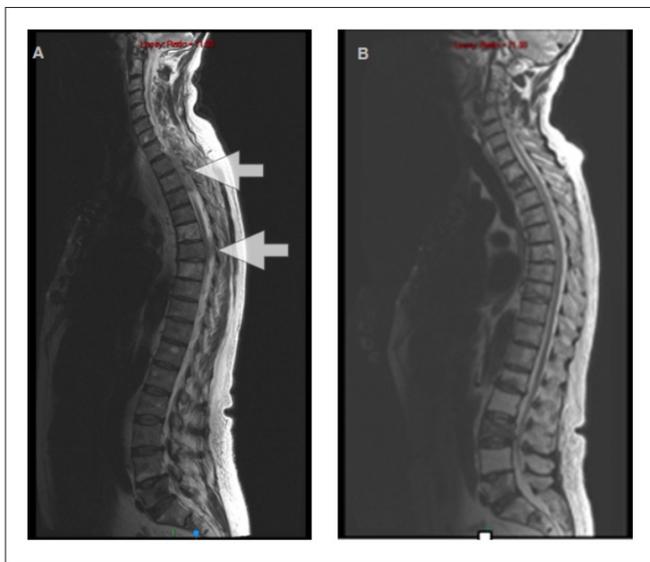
Mr JB's MRI of the whole spine taken a year apart. A: MRI at presentation showing cord compression at two levels as depicted by the arrows. B: MRI of the whole spine performed 12 months later revealed background osteoporotic changes only.
